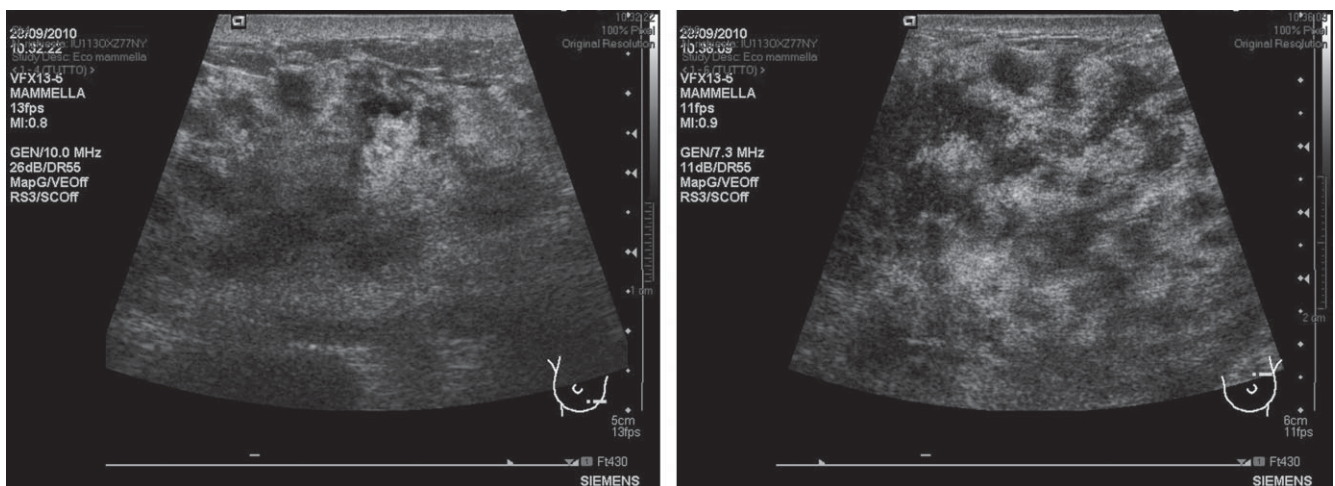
Breast ultrasound images showing heterogeneous echotexture and mild thickening of the skin.
